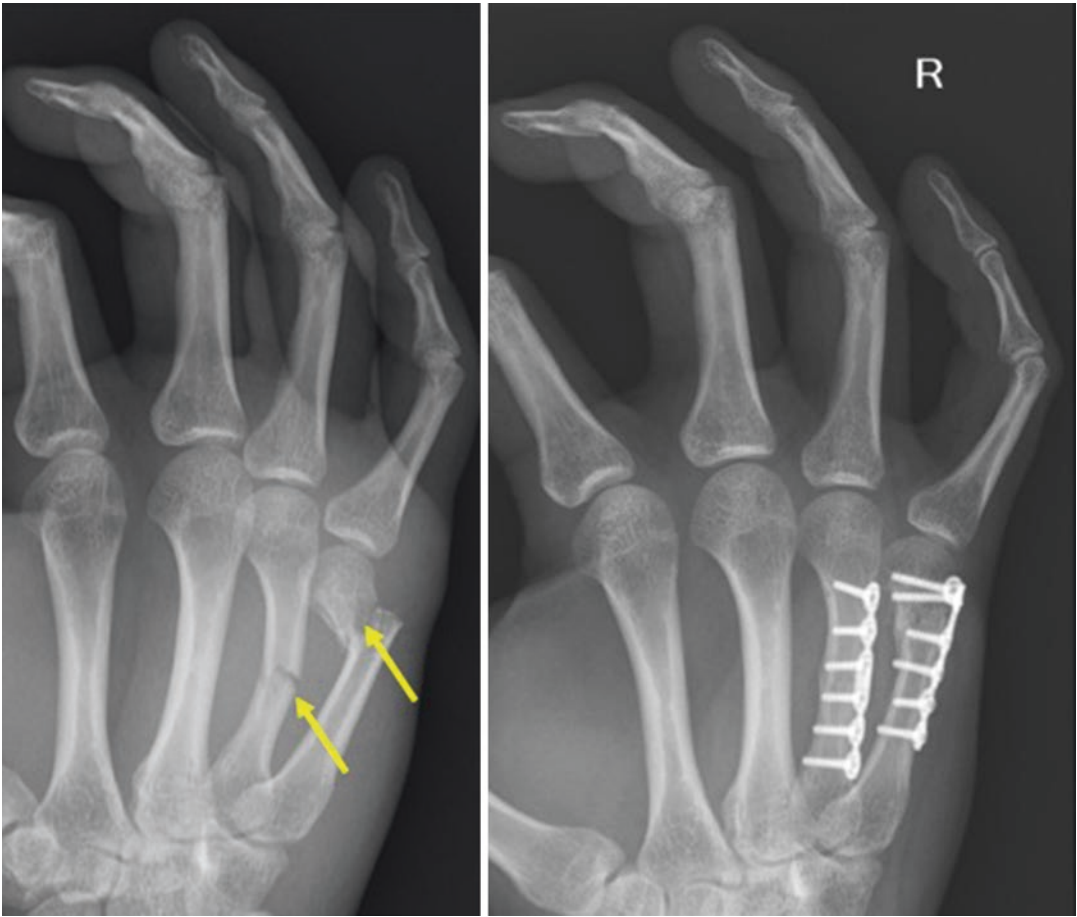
Radiographic images before (left) and after (right) surgical treatment of metacarpal fractures of the fourth and fifth ray resulting from improper breakfall.
